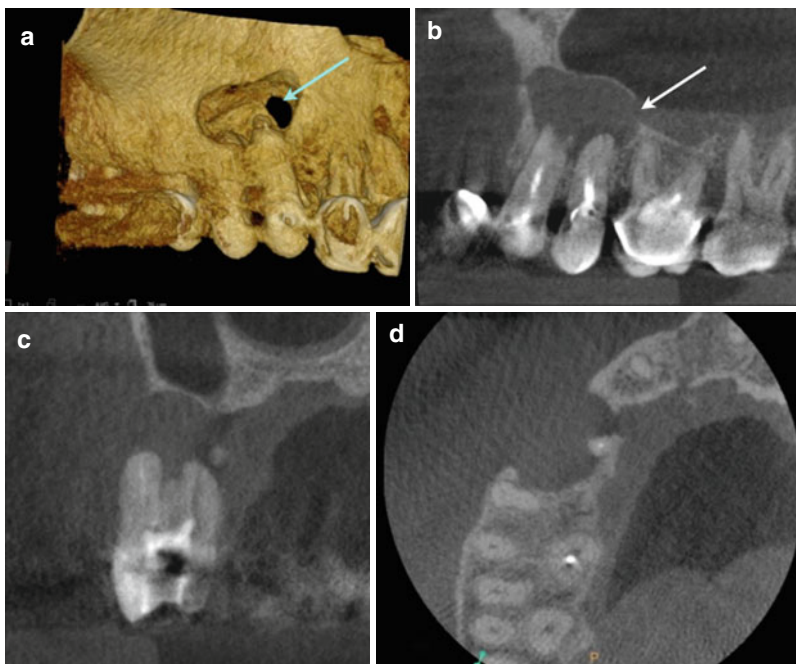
CBCT 3D rendering of teeth #12 and #13 referred for periapical surgery (a). Peroration of the maxillary sinus can be visualized (*blue arrow*). Sagittal view of teeth #12 and #13 (b). Perforation of the maxillary sinus noted (*white arrow*). Coronal view of tooth #12 demonstrating the through-and-through nature of the periapical defect (c). Axial view demonstrating the mesio-distal extent of the periapical defect (d)
